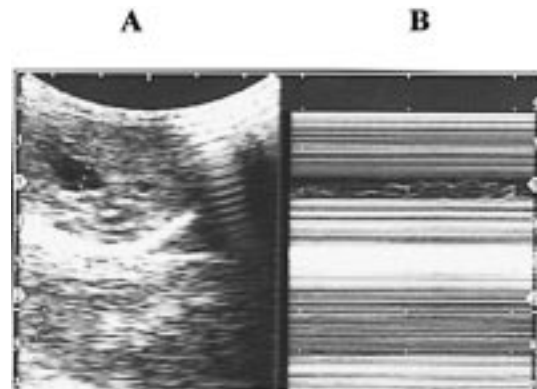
Ultrasound image of the same patient shown in Figure 1 obtained using a 3.5-MHz transducer. A B-mode image (A) shows lymphangiectasia at the site of the adult worms. The filaria dance sign in the M-mode image (B) is similar to that seen with the 7.5-MHz transducer (Figure 1).
